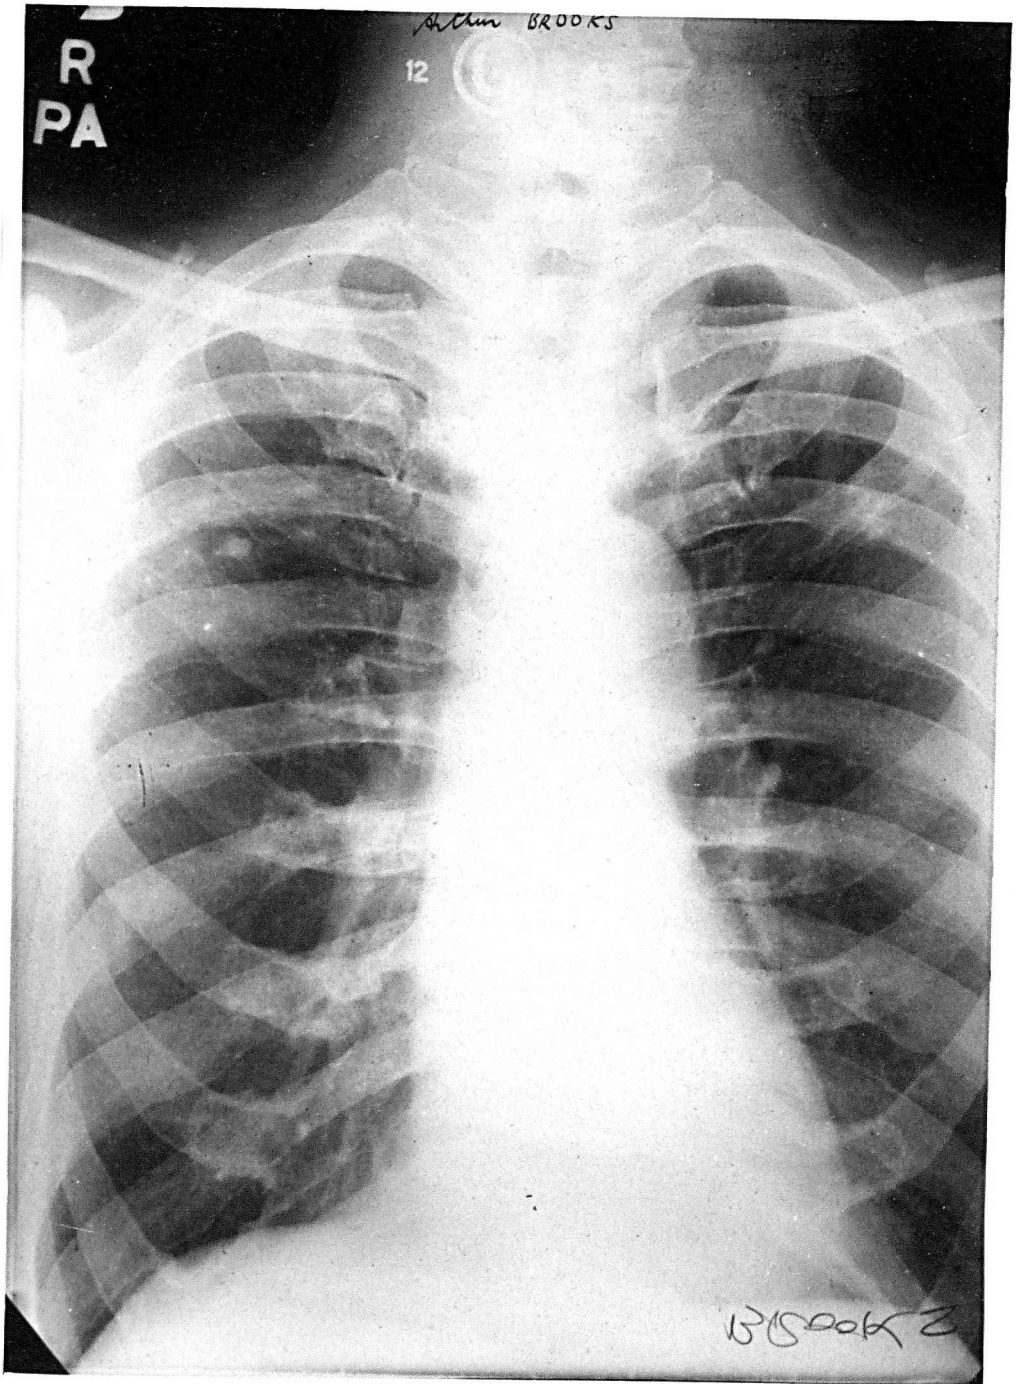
Case No. 7. A.B. Chest x-ray.
